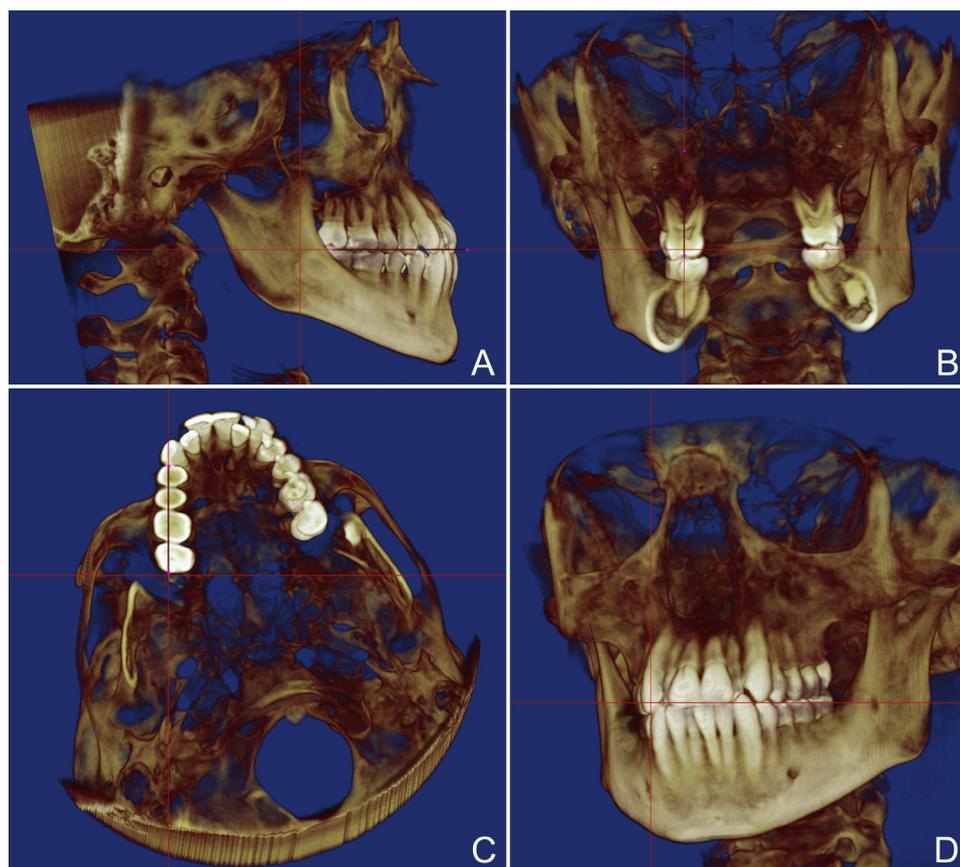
3D orientation of the posterior maxillary arch. A, Occlusal plane parallel to the horizontal reference line. B, Long axes of the posterior maxillary teeth parallel to the vertical reference line. C, Line of the contact points of the posterior teeth parallel to the vertical reference line. D, Final 3D positioning of the posterior maxillary arch used to obtain CBCT synthesized periapical radiographs with 0° projection geometry.
